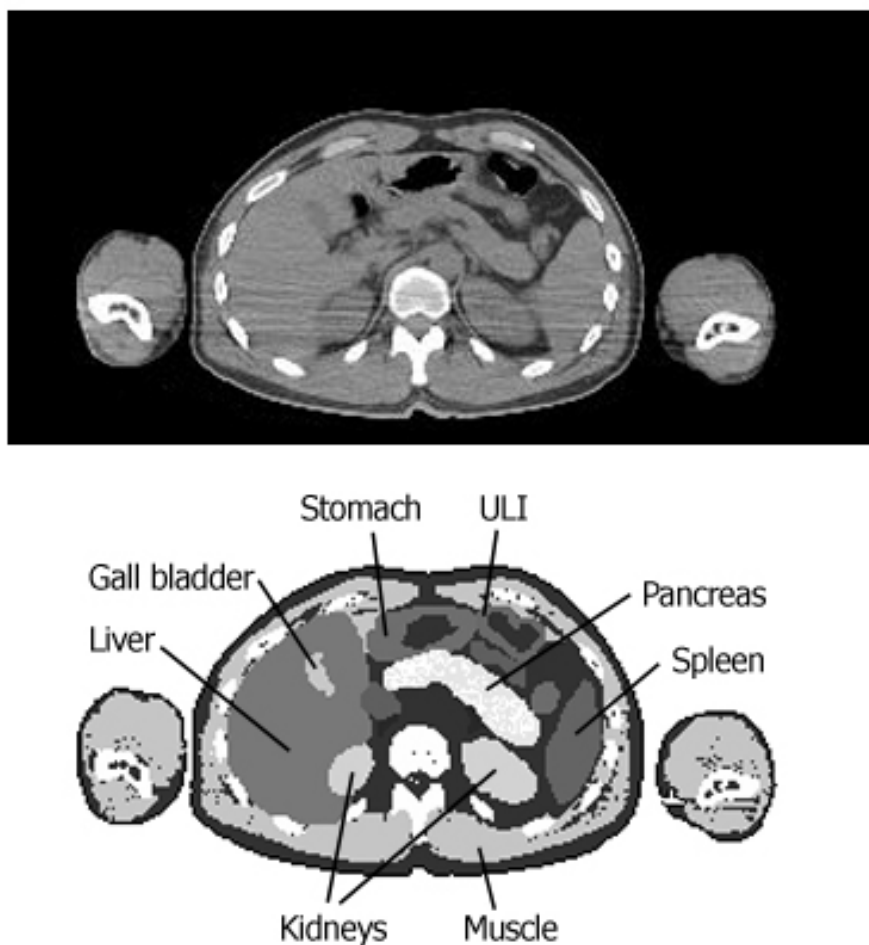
Example of segmentation for the CT image of lower trunk slices
